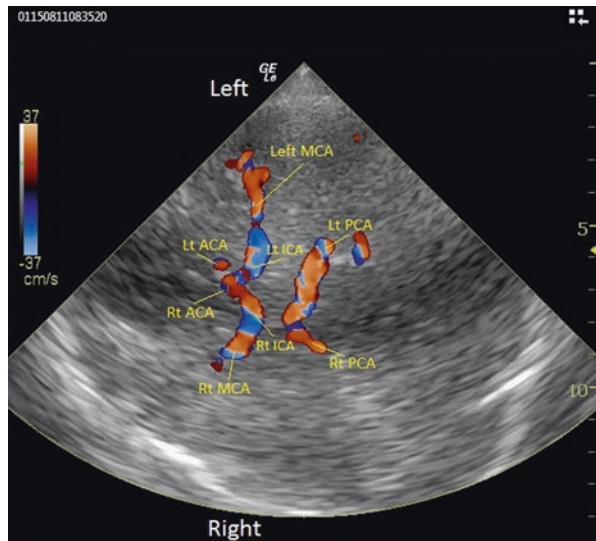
Circle of Willis defined by color-coded transcranial Doppler ultrasound
